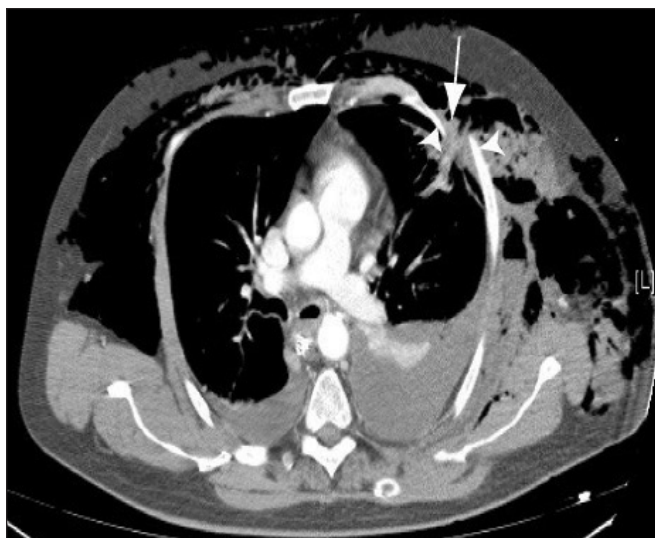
Computed tomography scan (bone window) showing 2 rib fractures (white arrowheads) and lung herniation (white arrow).
